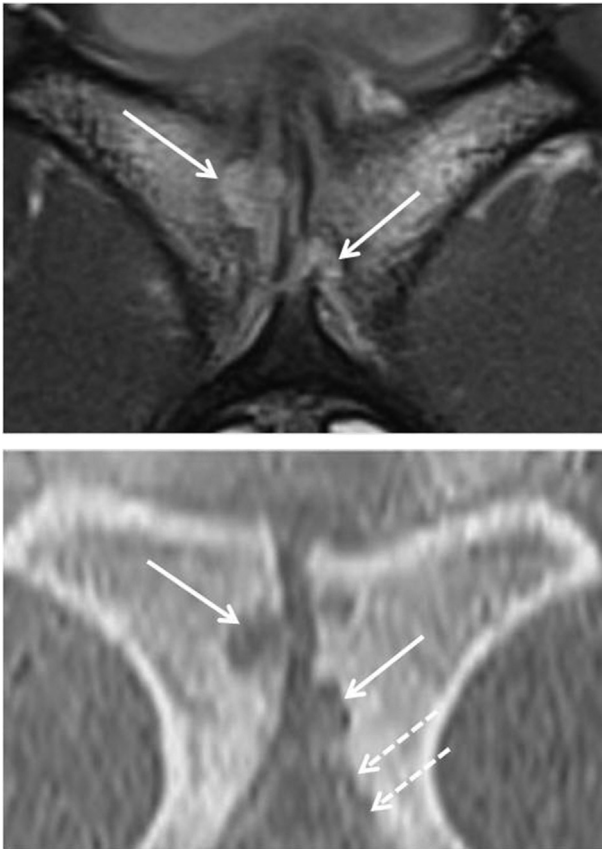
A 21-year-old elite AFL player with left groin pain, who subsequently developed bilateral groin pain. Coronal T2-weighted fat-saturated MRI (top image) showing open apophyses and marrow oedema bilaterally. Left and right “erosions” (arrows) are iso-intense to and in continuity with the high-signal pubic apophyses, compatible with pubic apophysitis. The player subsequently developed right groin pain. Coronal reformatted VIBE MRI (bottom image) shows more clearly a “cyst”-like erosion on the right and erosion on the left, slightly brighter than apophysis. There is a more ill-defined appearance of the more inferior apophysis and secondary ossification centre on the left (dashed arrow), compatible with apophysiolysis.
